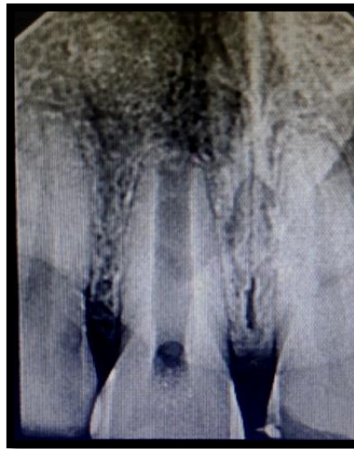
Radiograph showing the complete removal of guttapercha from the root canal in 11
